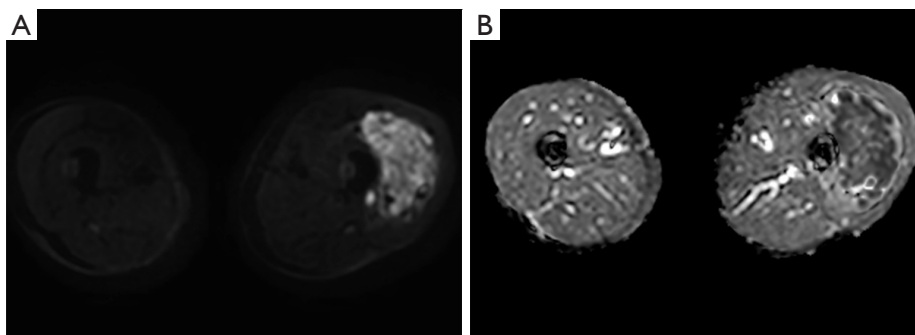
The axial DWI-weighted image at $b=800 \text{ mm}^2/\text{s}$ on 3.0-T MRI scanner shows a higher signal (A), and the corresponding gray-scale ADC map shows restriction (B). DWI, diffusion-weighted imaging; MRI, magnetic resonance imaging; ADC, apparent diffusion coefficient.
